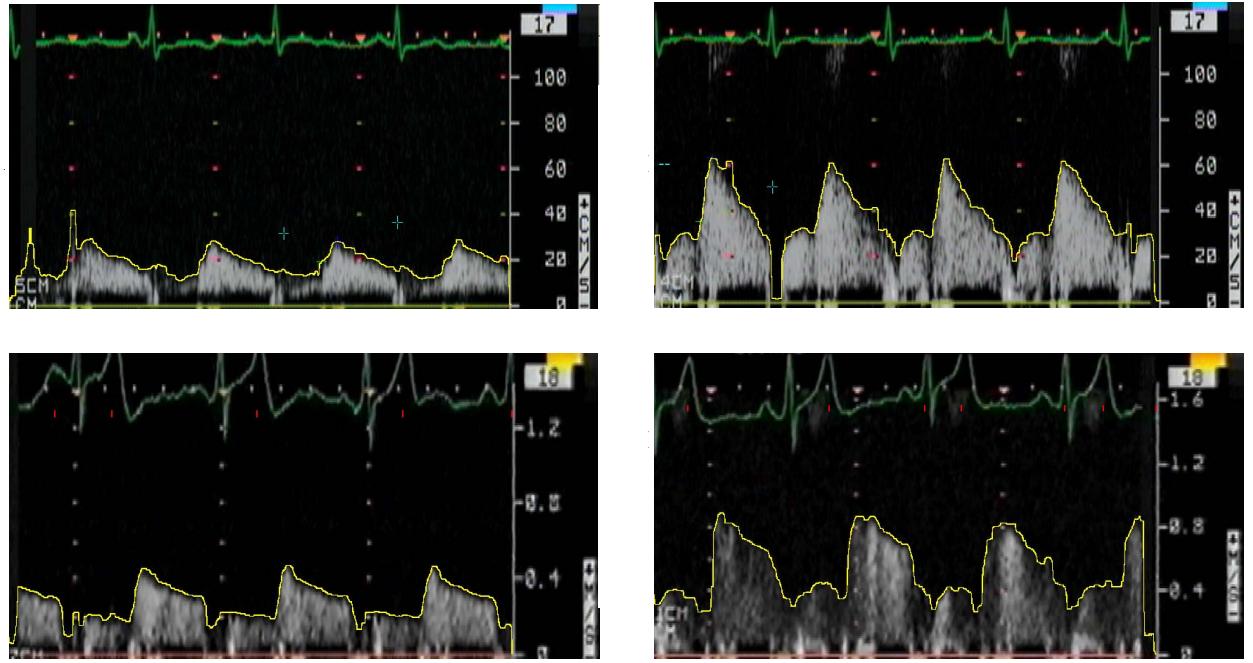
Doppler flow velocity profile with its contour semi-automatically detected and overimposed for visual assessment. Top panels: RA subject; bottom panels: N subject. Left: baseline; right: stress.
